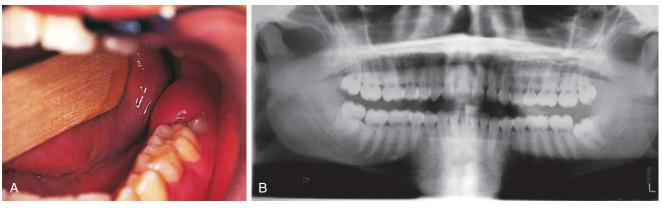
A, Pericoronitis involving a partially erupted third molar. Food particles and bacteria have become trapped under the residual overlying gingiva, resulting in inflammation and abscess formation. This condition can occur with eruption of any molar but is most common with partially erupted third molars (wisdom teeth). B, Panoramic radiograph demonstrating the presence of erupted maxillary third molars and mandibular right third molar but only partial eruption of the left mandibular third molar.
